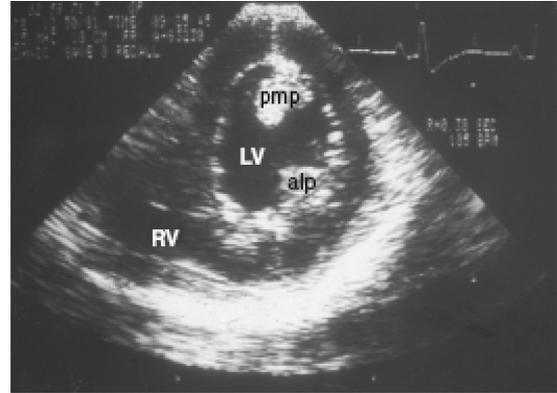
Two-dimensional image (transgastric midpapillary short-axis view) recorded from the first 2-dimensional Hanrath-Souquet transesophageal probe used in surgery at the University of California, San Francisco, circa 1982.
